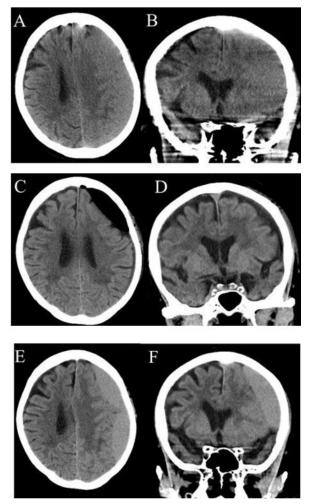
Head computed tomography (CT) was performed at the first time admission (A, B) and after the first time irrigation (C, D). Head CT was performed at the second time admission with chorea recurrence (E, F). A, C, and E show head CT with axial view. B, D, and F show head CT with coronal view.
